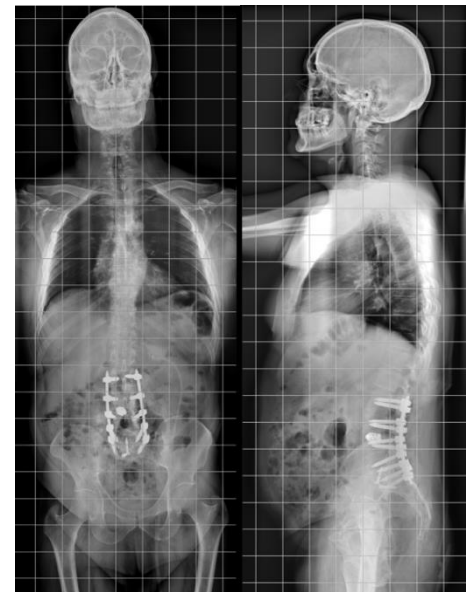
A-B. Postoperative (EOS) X-ray showing the new instrumentation L2-S1 and the cage L5-S1 via ALIF
